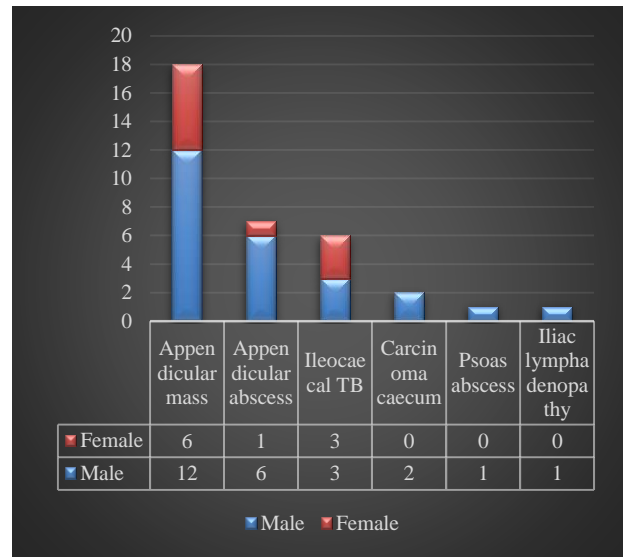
Distribution of different pathologies of RIF masses diagnosed in CT.
